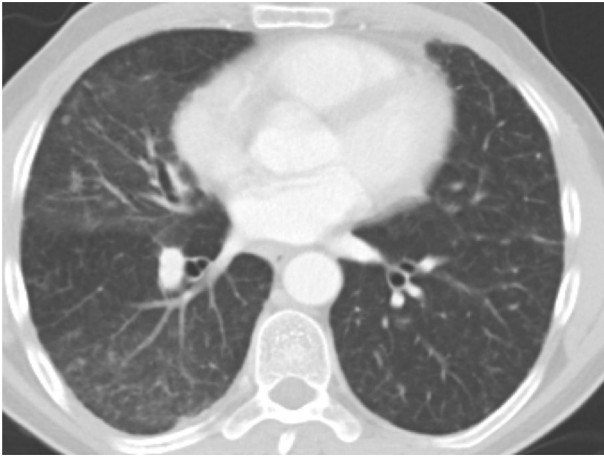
CT chest scan showing a lower lobe-predominant, fine reticular pattern with ground-glass and peribronchovascular nodules.
